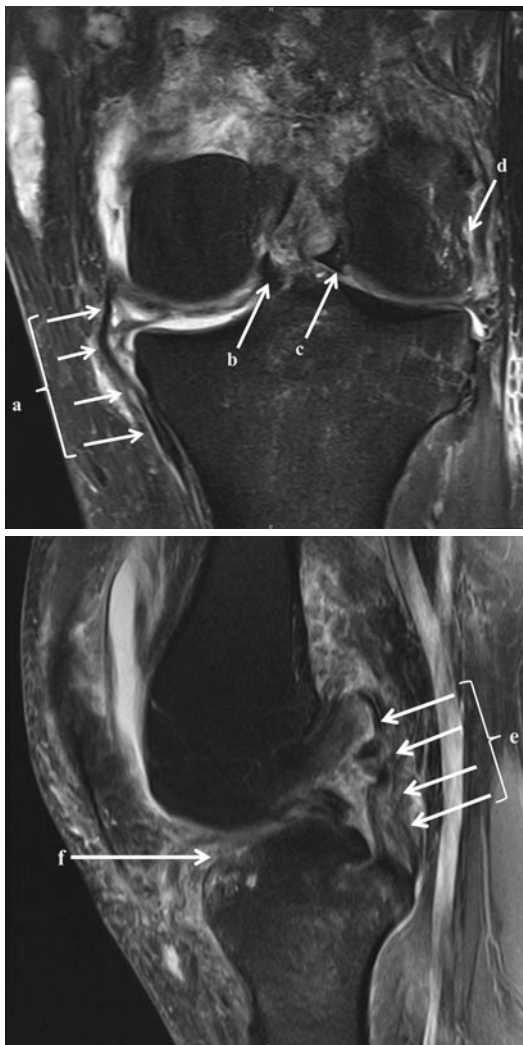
MRI images of 55-year-old injured skier with total knee dislocation. *Top*: coronal view. Damaged structures are as follows: (A) MCL tear, (B) medial meniscus bucket-handle tear, (C) lateral meniscus bucket-handle tear, and (D) popliteus tendon tear. *Bottom*: sagittal view. Damaged structures are as follows: (E) PCL tear and (F) ACL tear
